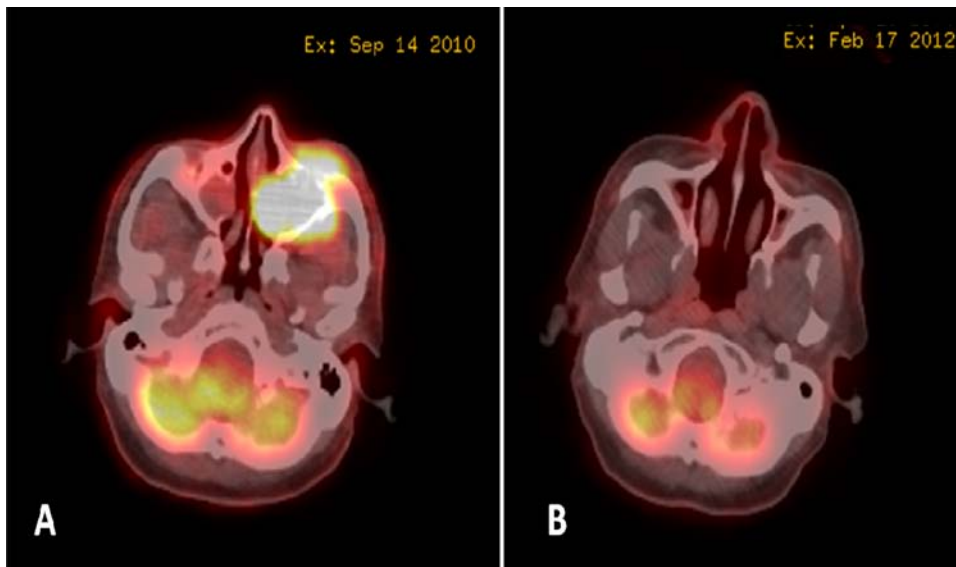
A, Computed tomography and positron emission tomography scans before initiation of chemotherapy and B, 17 months after diagnosis.
